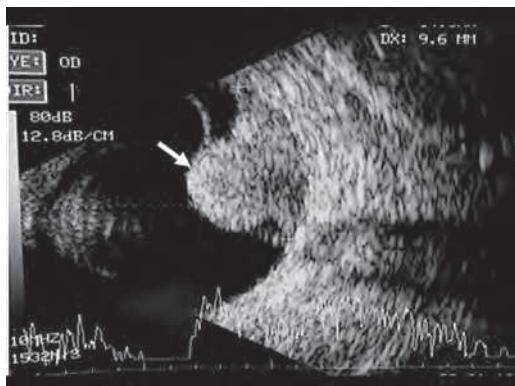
Combined ultrasonography A- and B-scan showing a mushroom shaped mass arising from the choroid with surrounding subretinal fluid and homogenous internal reflectivity. A-scan shows moderate spikes. There is acoustic hollowing towards the base of the tumor
